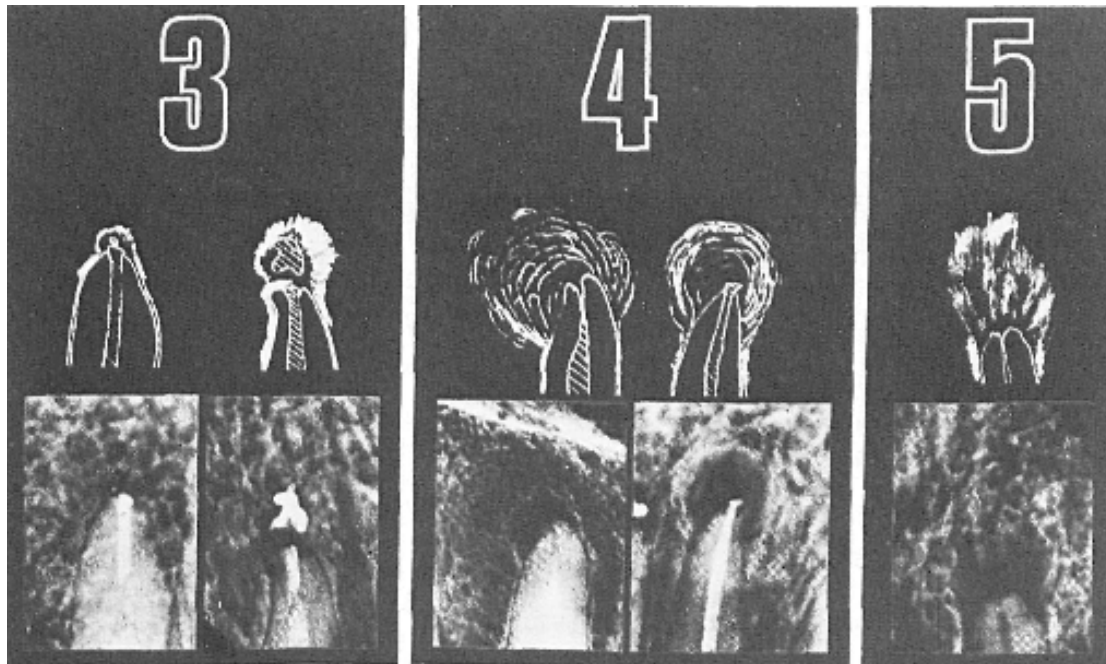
PAI reference classification 3, 4 and 5 (From “The periapical index: a scoring system for radiographic assessment of apical periodontitis.” Orstavik et al. 1986)
